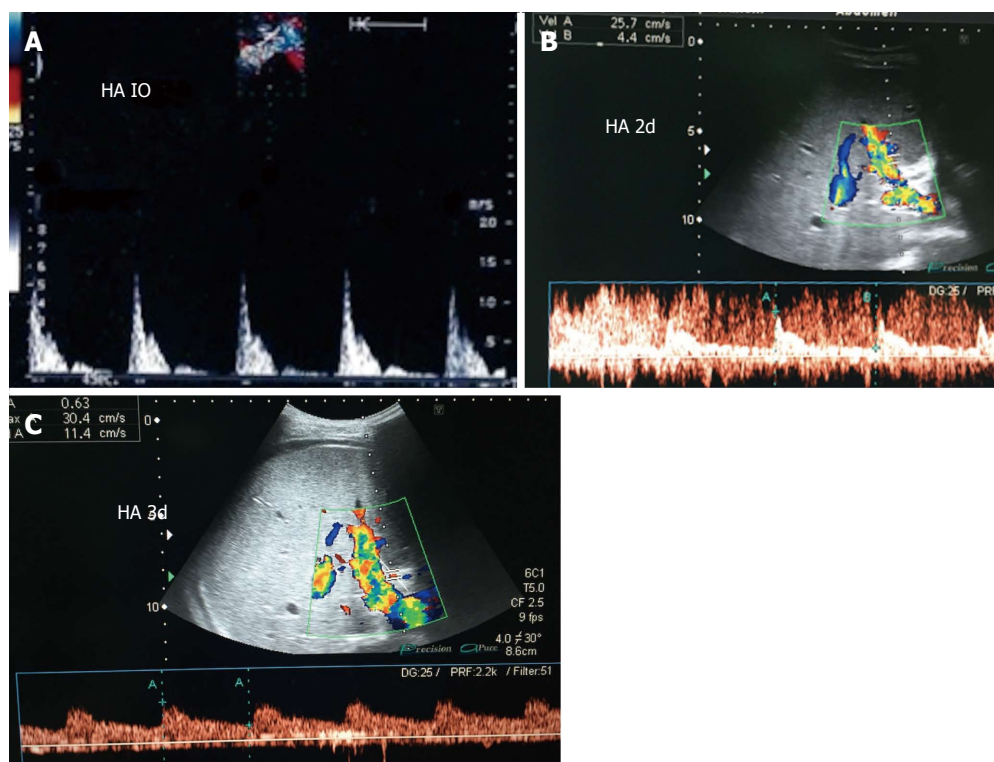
Intra- and post-operative hepatic artery vasospasm. A: Intraoperative Doppler US image showing high resistance of the HA with damped diastolic flow and normal systolic upstroke; B and C: Doppler US images of the HA, 2 d and 3 d post-operative after systemic administration of vasodilators, showing improvement of the diastolic flow and correction of the normal biphasic Doppler waveform. HA: Hepatic artery; IO: Intra-operative.
